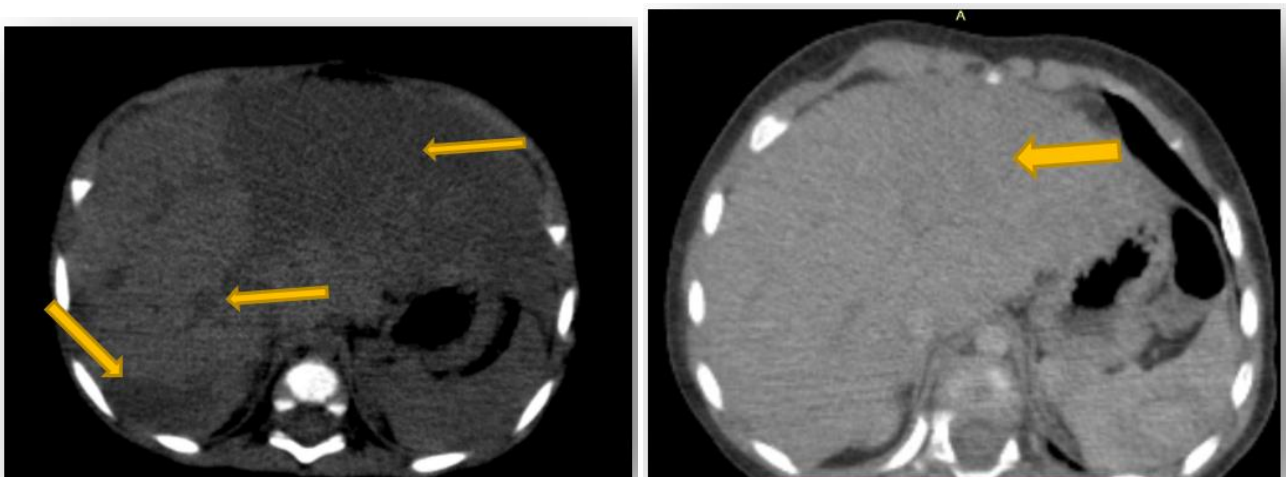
Axial CT images showing heterogeneous liver containing multiple nodular and geographic lesions (yellow arrow), hypodense on unenhanced CT, demonstrating peripheral enhancement following contrast injection
